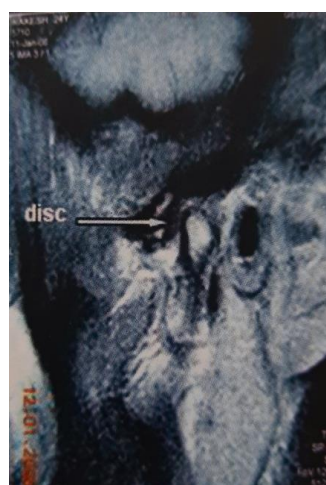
MRI Rt. Closed mouth.
